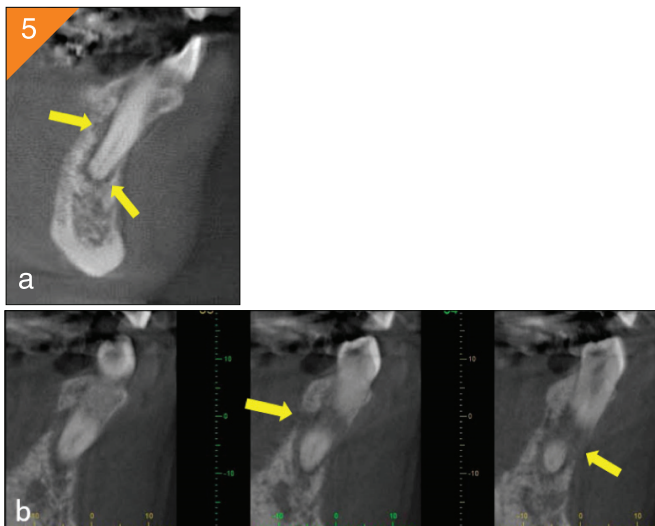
a) Cross sectional view of CBCT data at the #28 area. Note irregular PDL widening, destruction of lamina dura. b) Cross sectional view from CBCT data. Note localized interruption of buccal and lingual cortical plates with no expansion.
